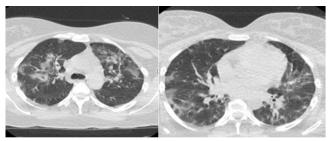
Computed tomography showed bilateral consolidation in the lung
